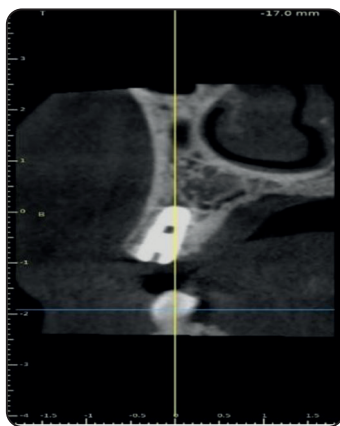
A photo-radiograph showing a postoperative CBCT image
